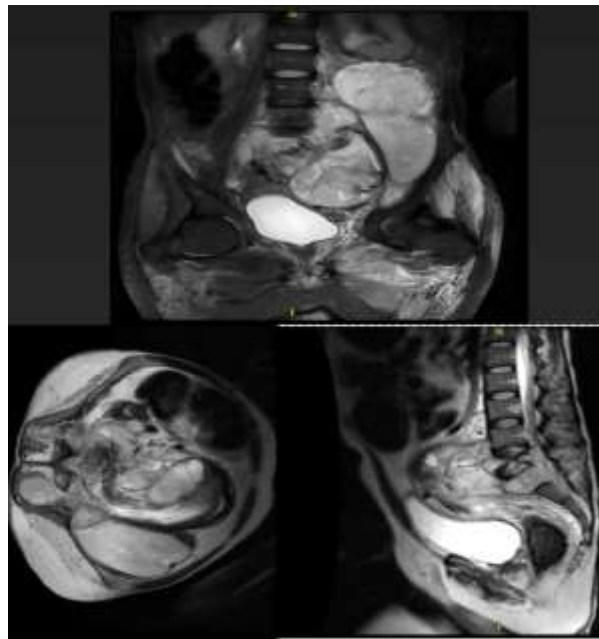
Contrast Enhanced MRI of Lumbar Spine
